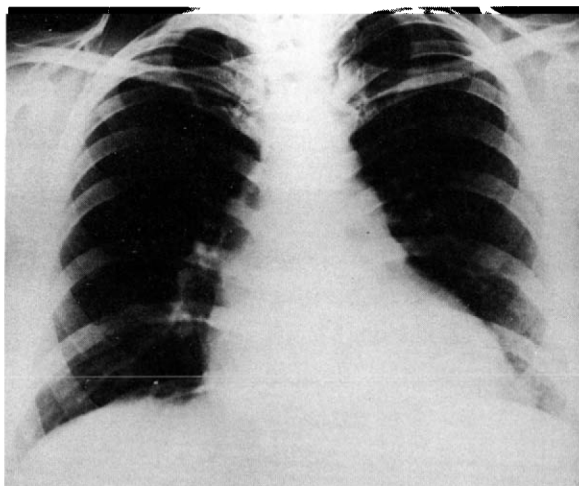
Chest roentgenograph in 1969 shows slight prominence of both main pulmonary branches and slight peripheral tapering.
